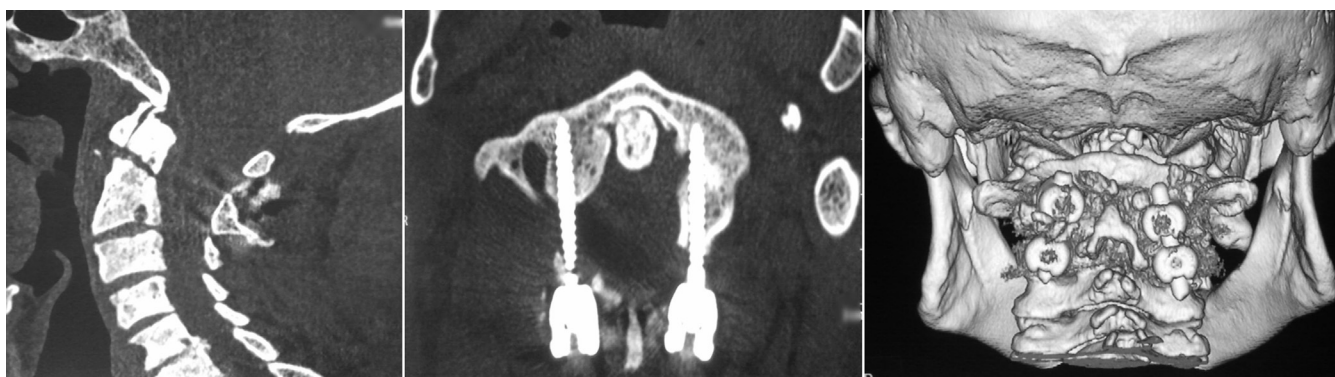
Postoperative radiographs of craniocervical junction (CVJ) after the C1 lateral mass and C2 pars screw and rod fixation using posterior approach—(Left) sagittal CT, (Middle) axial CT, and (Right) 3-D reformatted posterior view showing reduced C1–C2 joint and odontoid process well aligned with the C2 vertebral body.
